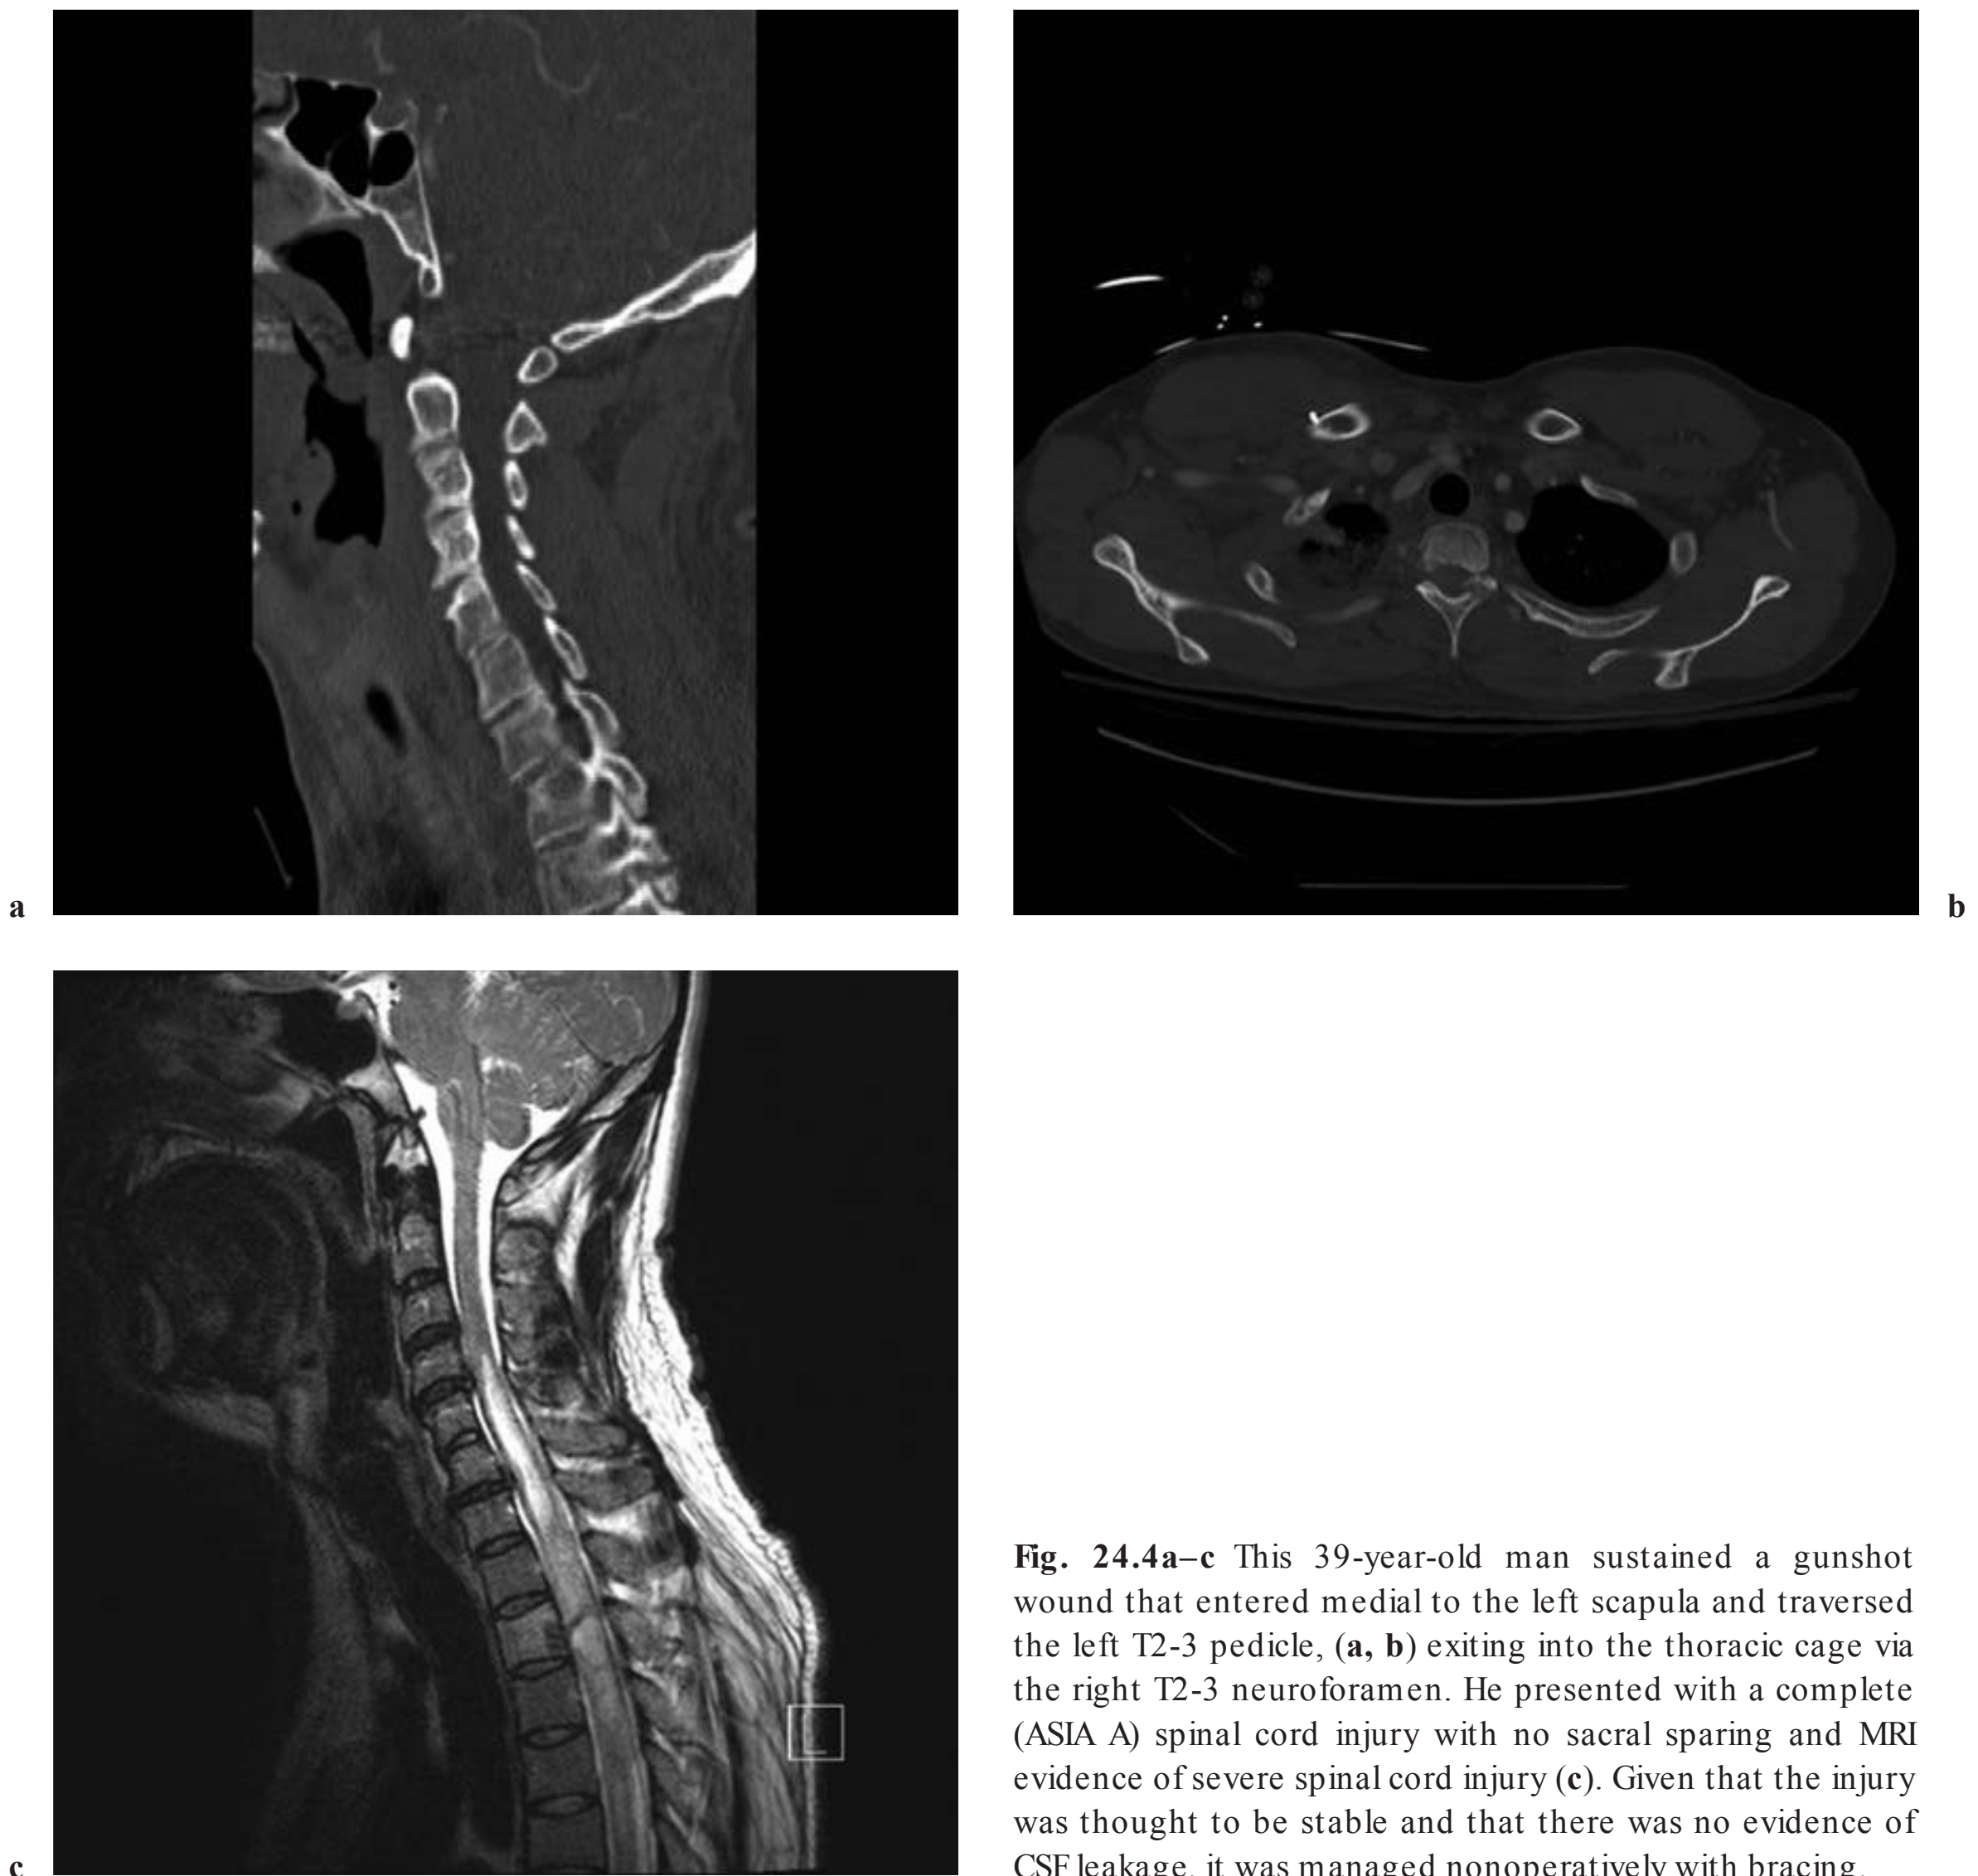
This 39-year-old man sustained a gunshot wound that entered medial to the left scapula and traversed the left T2-3 pedicle, (a, b) exiting into the thoracic cage via the right T2-3 neuroforamen. He presented with a complete (ASIA A) spinal cord injury with no sacral sparing and MRI evidence of severe spinal cord injury (c). Given that the injury was thought to be stable and that there was no evidence of CSF leakage, it was managed nonoperatively with bracing.
